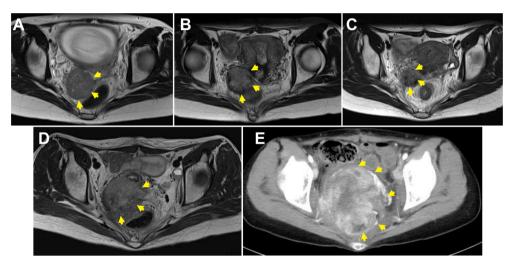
Time-series changes in magnetic resonance imaging (MRI) and computed tomography (CT). A) MRI T2-weighted axial image (25 weeks of gestation). B) MRI T2-weighted axial image (4 weeks postpartum). C) MRI T2-weighted axial image (12 weeks postpartum). D) MRI T2-weighted axial image (22 weeks postpartum). E) Contrast-enhanced CT (27 weeks postpartum). Arrows show change in tumor size. Partial response was achieved by radiotherapy (C), but the tumor promptly recurred (D). Rectum permeation finally developed, and the bleeding from the anus lasted (E).
